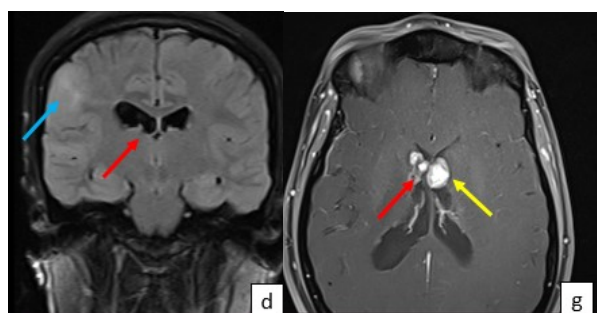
a) – Clinical image of the patient showing multiple facial angiofibromas (red arrow) b, c) – Hypomelanotic macules noted in lower back and upper arms (red arrow) and d) – MRI Flair image showing cortical tubers in right parietal region (blue arrow) and subependymal nodules (red arrow) e) – T2 heterointense subependymal nodules noted with f) – few showing gradient blooming indicating calcification (red arrow) g) – Few subependymal nodules showing contrast enhancement (red arrow) and a large lesion consistent with SEGAs (yellow arrow) noted, h) – CT abdomen showing bilateral renal AMLs (blue arrows), i) – CT bone window showing bone islands (green arrow).
